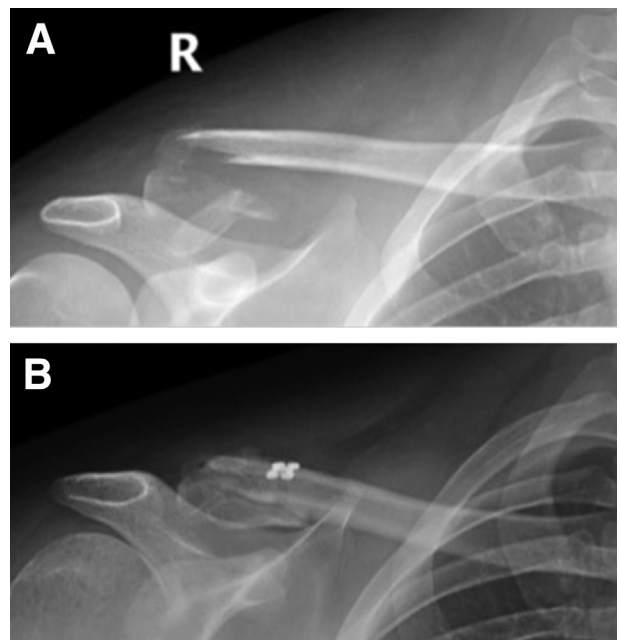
Radiograph A is an anteroposterior (AP) radiograph of the right (R) clavicle demonstrating a distal third clavicle fracture with superior displacement of the proximal fragment. Radiograph B is an AP radiograph of the right clavicle status post—arthroscopic assisted open reduction and coracoclavicular ligament reconstruction.
